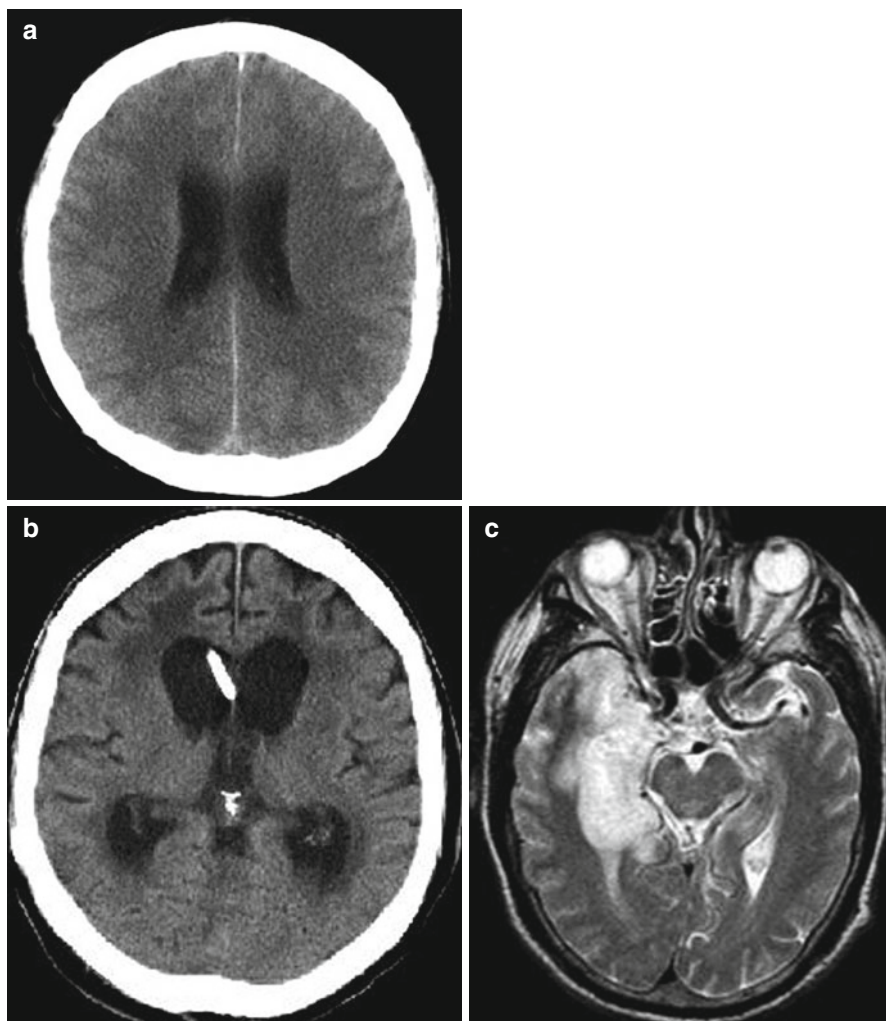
CT of a patient with bacterial meningitis. (a) Diffuse brain edema. (b) Hydrocephalus. (c) Herpes simplex-encephalitis with temporal lobe involvement in T2 weighted MRI imaging. (d) Multiple cerebral emboli complicating bacterial endocarditis in diffusion weighted imaging MRI
